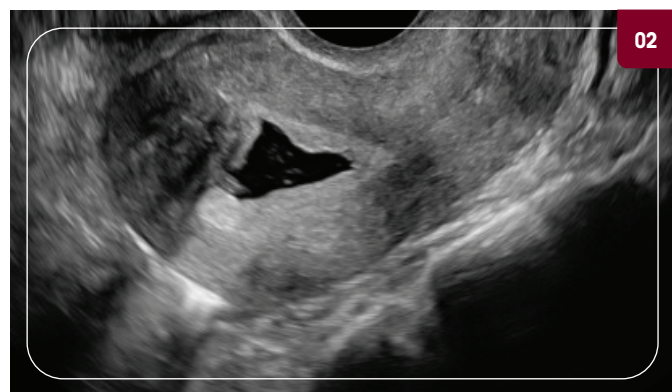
Mid-sagittal transvaginal saline ultrasound identifying the fibroid to be International Federation of Gynecology and Obstetrics (FIGO) Type 2 with a submucosal component but $\geq 50\%$ of the fibroid located intramural.
